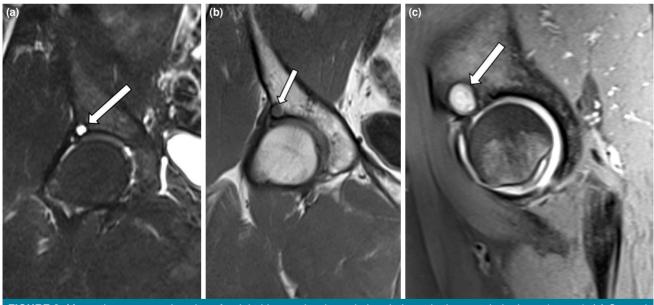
Magnetic resonance imaging of a right hip are showing subchondral cyst in the acetabular bone (arrows). (a) Coronal T2-weighted sequence, (b) Coronal T1-weighted sequence, (c) Sagittal T2-weighted sequence.
